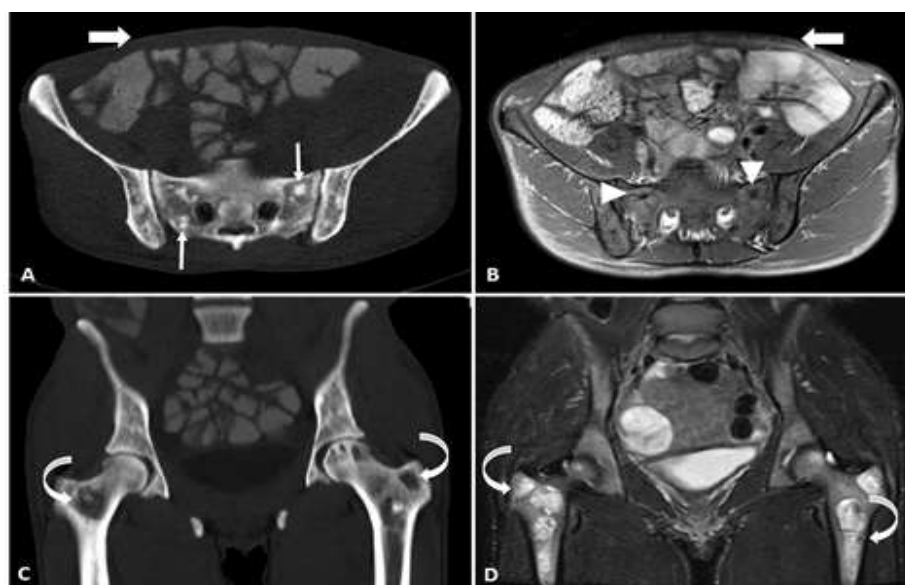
Imaging findings of the patient. Sclerotic bony lesions (arrows) in axial CT scan (A) with corresponding hypointense foci (arrow heads) in T1-weighted MRI (B) of the pelvis. Considerable loss of subcutaneous fat is also noted (thick arrows). There are well-defined cystic appearing lytic lesions in coronal CT scan (C) and T2-weighted MRI (D) of proximal femurs (curved arrows).
